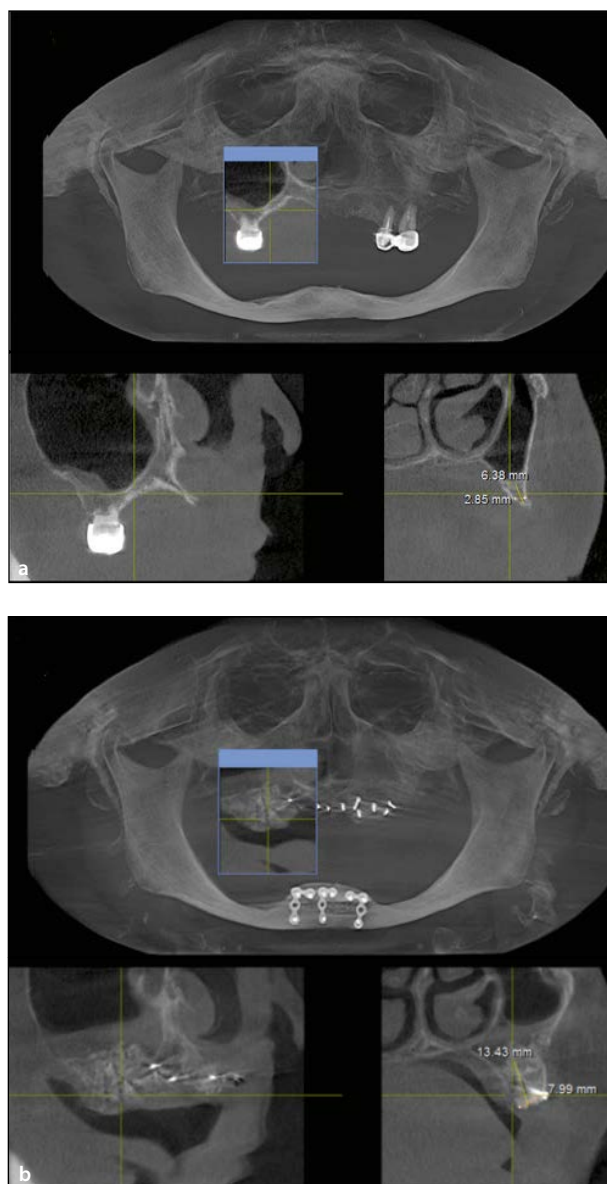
CBCT scans. (a) Baseline. (b) 6 months after reconstruction.
